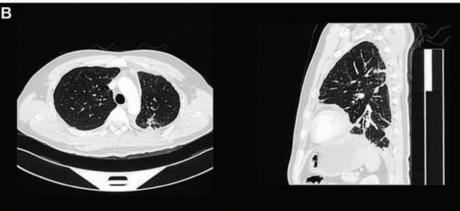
A*, CT scan of thorax before initiation of crizotinib. *B*, CT scan of thorax after 1 month therapy of crizotinib. CT, computed tomography.
